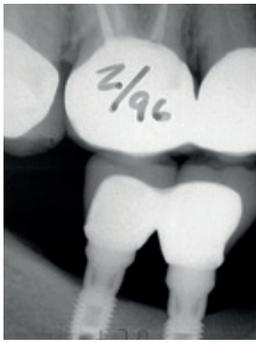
A 1996 bite-wing radiograph of implant prostheses replacing teeth Nos. 29 and 30. The bone level has been stable for 6 years.
